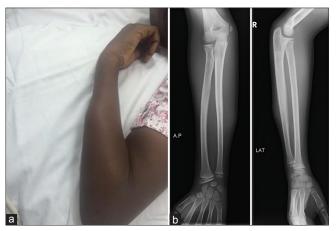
(a) Photograph of the first child's right forearm showing soft-tissue swelling in the distal third. (b) Plain radiographs of the forearm. Soft-tissue swelling is noted adjacent the left ulnar with no calcifications *in situ*
